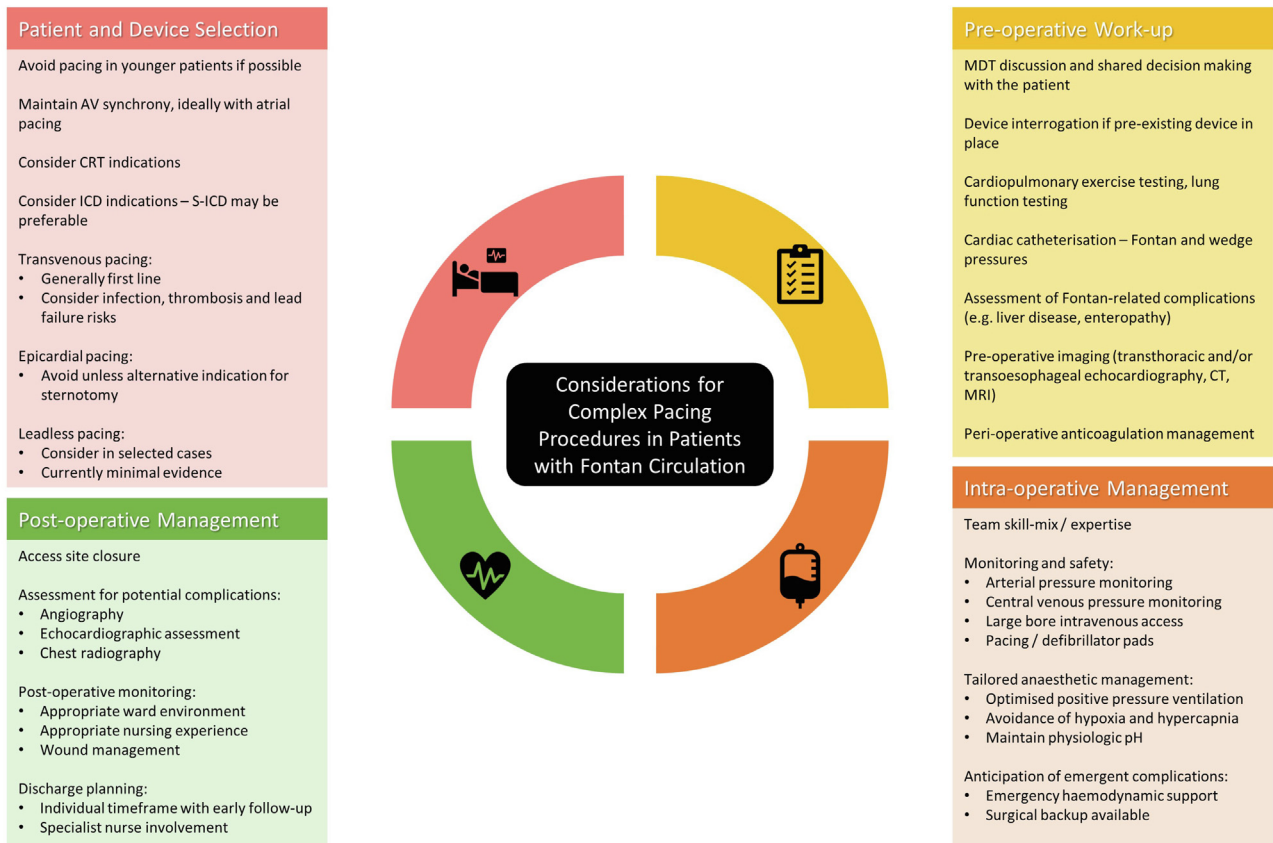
Considerations for complex pacing in patients with Fontan circulation. AV = atrioventricular; CRT = cardiac resynchronization therapy; CT = computed tomography; ICD = implantable cardioverter-defibrillator; MDT = multidisciplinary team; MRI = magnetic resonance imaging; S-ICD = subcutaneous implantable cardioverter-defibrillator.
